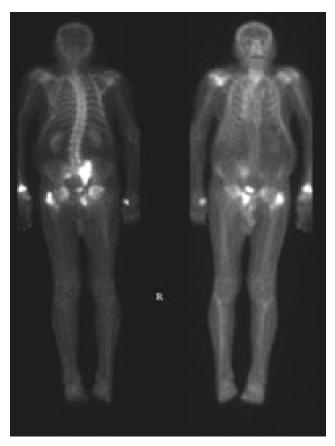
Technetium-99m hydroxymethylene diphosphonate (oxidronate sodium) bone scintigraphy shows increased uptake in right rami, sacrum, left trochanter, right proximal humerus, and left distal radius. Scoliosis is evident.
